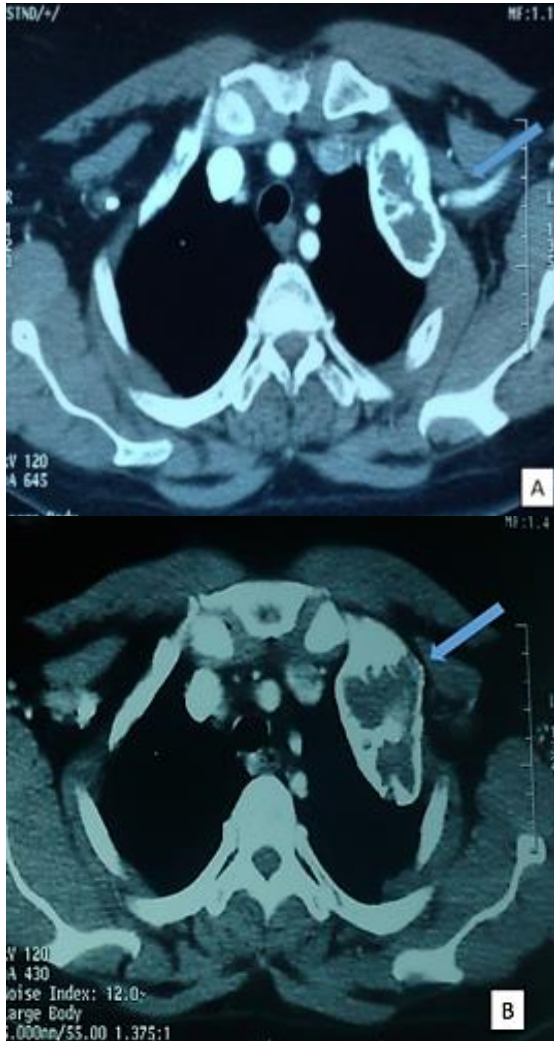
Chest CT showing the mass with spindle-shaped of the rib and bone cortex thinning of the first left rib (Fig.2A) with intimate contact with the left subclavian artery (Fig.2B).
